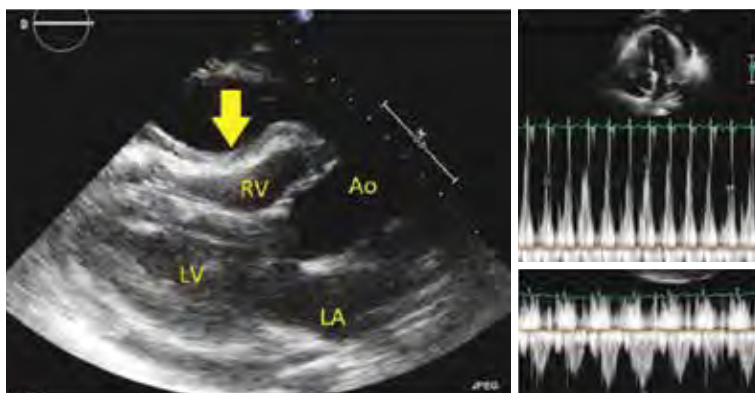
Young male with relapsing pericarditis who presented to the ER with hypotension and tachycardia, pulsus paradoxus, among other clinical manifestations. Echocardiogram performed in the ER, showed diastolic collapse of the right cavities (yellow arrow) and significant respiratory variation in both aortic outflow (down right) a mitral inflow velocities (upper right), echocardiographic findings suggestive of cardiac tamponade. Echo guided pericardiocentesis was performed and a few moments after decompressing the pericardium, patient became hemodynamic stable.
